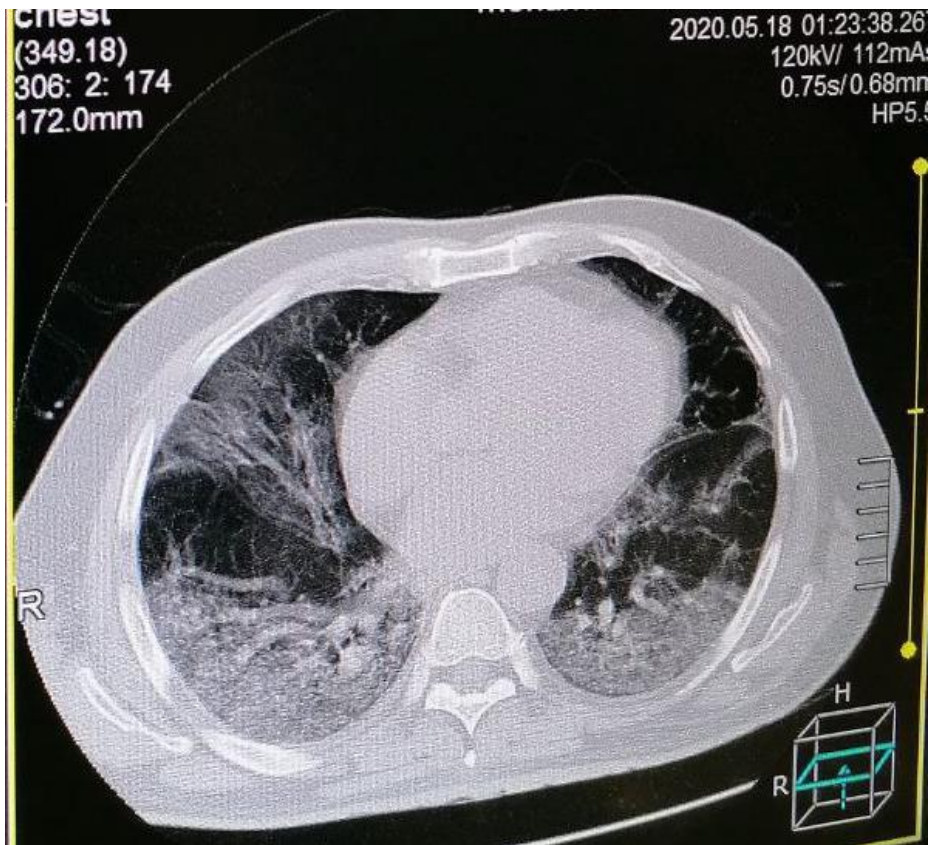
COVID-19 pneumonia with typical imaging features according to the Radiological Society of North America (RSNA) chest CT classification system . Axial nonenhanced chest CT images (lung window) in a 59-year-old man with positive RT-PCR test results for SARS-CoV-2, show bilateral areas of ground-glass opacities (arrows) in a peripheral distribution.
